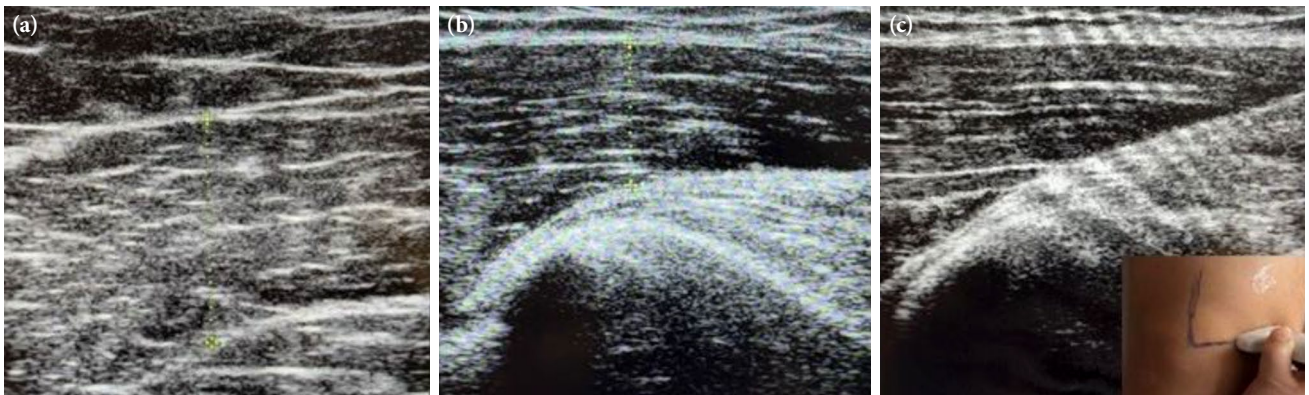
Ultrasonographic images of (a) vastus medialis, (b) vastus medialis oblique muscle 23 thickness and (c) vastus medialis oblique fibre angle measurements.
